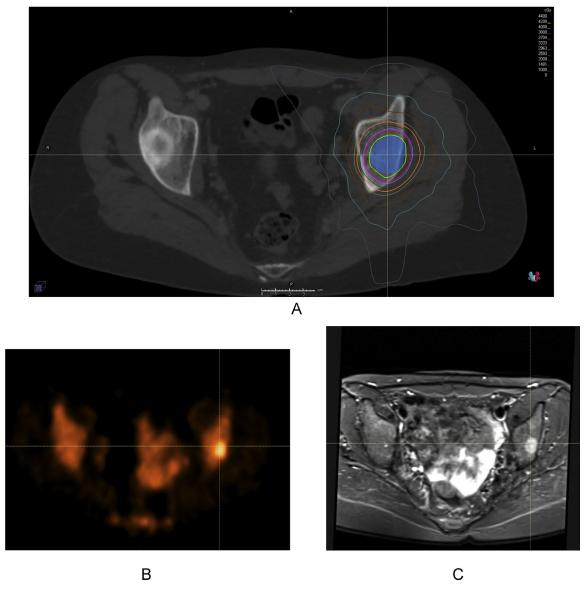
(A) A 15-year-old girl with left acetabular bone metastasis from recurrent Ewing sarcoma. The lesion was prescribed 40 Gy in 5 fractions; the planning target volume is shown in blue color wash. Delineation of the metastasis was guided by fused (B) positron emission tomography and (C) Magnetic resonance imaging (short tau inversion recovery [STIR] sequence).
